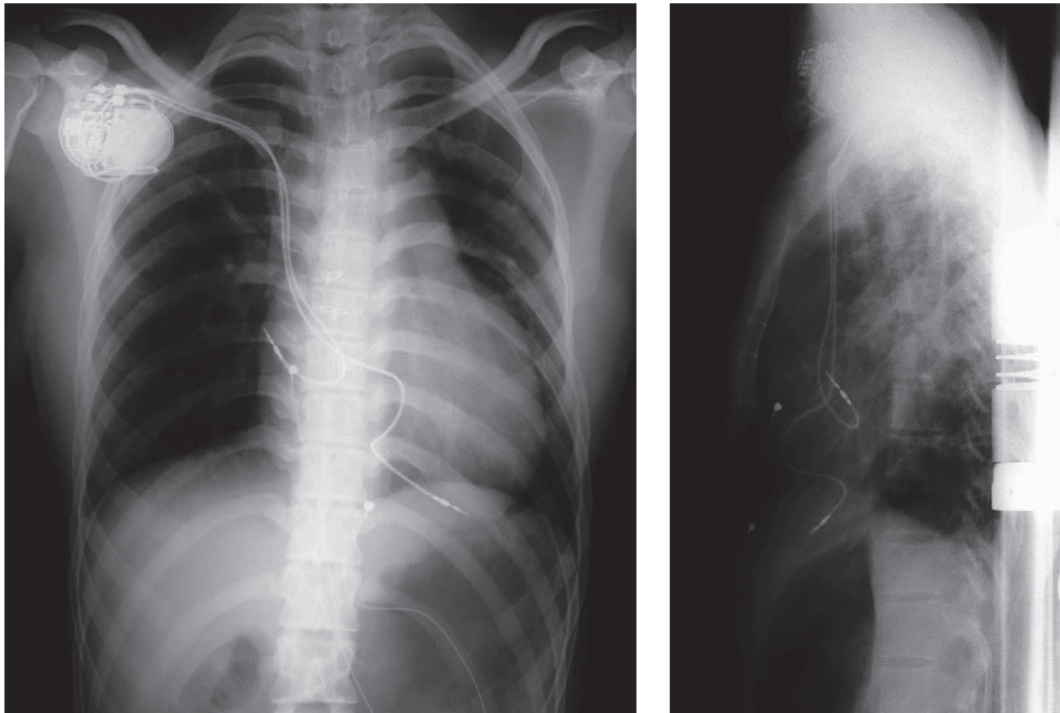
Chest X-ray taken after her generator was exchanged (2013.8.5).
